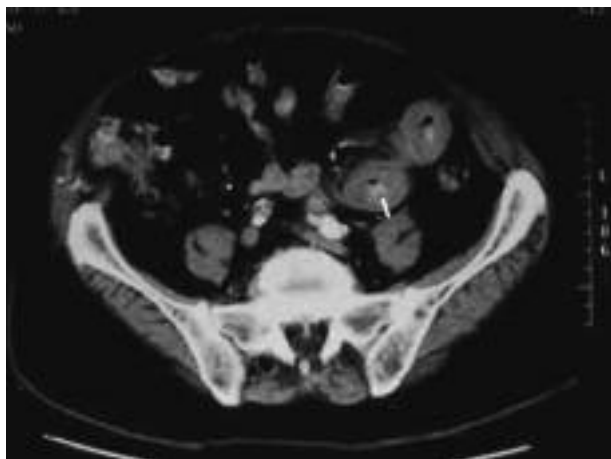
Contrast-enhanced abdominal Computerized Tomography (CT) showed intraluminal hyperdensity (arrow).
